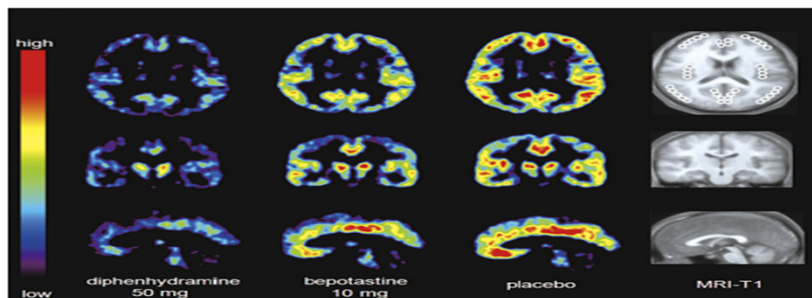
Images of BPR of ^{11}C -doxepin in the human brain. The BPR images taken from healthy male subjects ($n = 8$) using PET 12 hours after oral diphenhydramine 50 mg (left), bepotastine 10 mg (middle), or placebo (right) administration, and their MRI-T1 images (far right) are shown in the transaxial (top), coronal (middle), and sagittal (bottom) sections for each treatment. White circles indicate the ROIs. The brain image of each subject was transformed to fit stereotaxic brain space (spatial normalization) and was averaged across each treatment to generate the mean images. Note that treatment with diphenhydramine results in significantly lower BPRs than the other 2 treatments.
